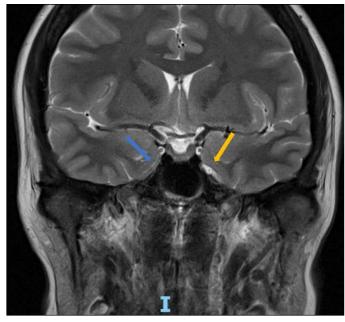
FINDINGS: Coronal T2 MRI of the brain demonstrates non-visualization of the right Meckel's Cave (blue arrow) and a normal left Meckel's cave (yellow arrow).
